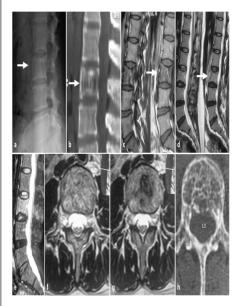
A 36 year old patient with irregular trabecular pattern and poorly defined lytic zone (a, b) involving L3 vertebra. T1, T2 and STIR (c, d, e) MR imaging clearly define the lesion. CT (h) shows involvement of the entire body with irregular honey-comb appearance.
